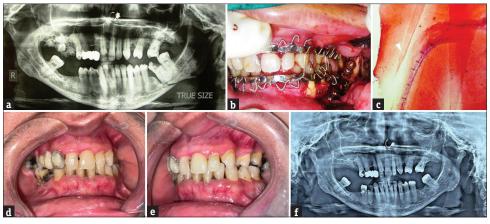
(a) Digital orthopantomogram showing the fracture in the left body region of mandible. (b) Intraoperative view of the fractured fragments reduced and immobilized by miniplate fixation. (c) Microphotograph of the mandibular left second molar which was removed intraoperatively and appreciate the union between the bone and the cementum. (d and e) Occlusion of the patient 14 years following the surgery. (f) Orthopantomogram 14 years following the surgery
